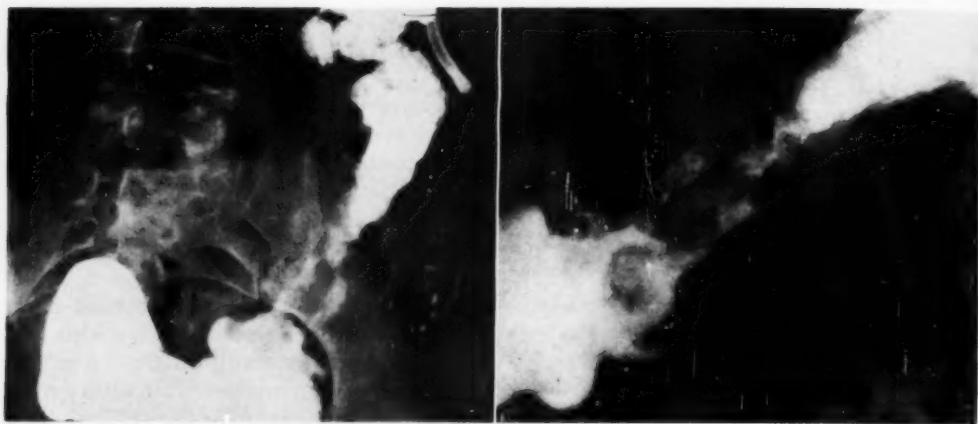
Case 3: Carcinoma of sigmoid (residual barium within the colon from examination at another hospital). Urokon, 30 per cent, was injected into the rectum. Roentgenogram shows a partially lobulated 10-cm. defect in the sigmoid. Some contrast substance lies within a 9-cm. cavity extrinsic and lateral to the colon. No pyelogram was visible on the full-size films.
